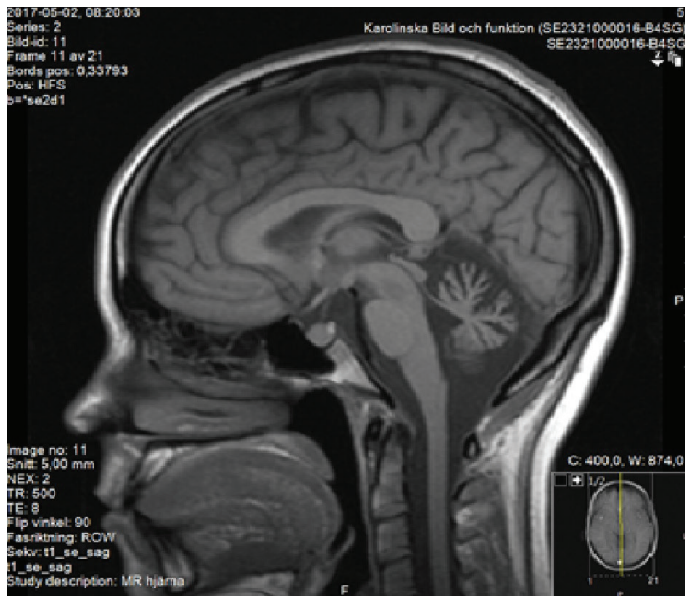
Neuroimaging in AOA2. Midsagittal T1-weighted brain MRI of the patient at age 27 showing moderate cerebellar atrophy and enlarged interfolial spaces.
